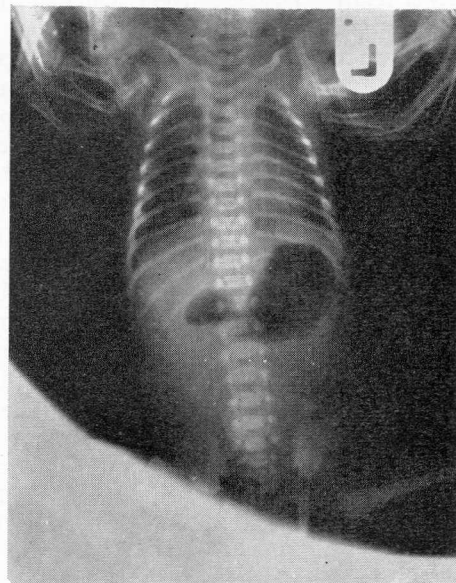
Double sign of duodenal atresia. The bubble on the left side is that of the stomach and that on the right is due to the distended proximal duodenum. (Erect X-ray).
